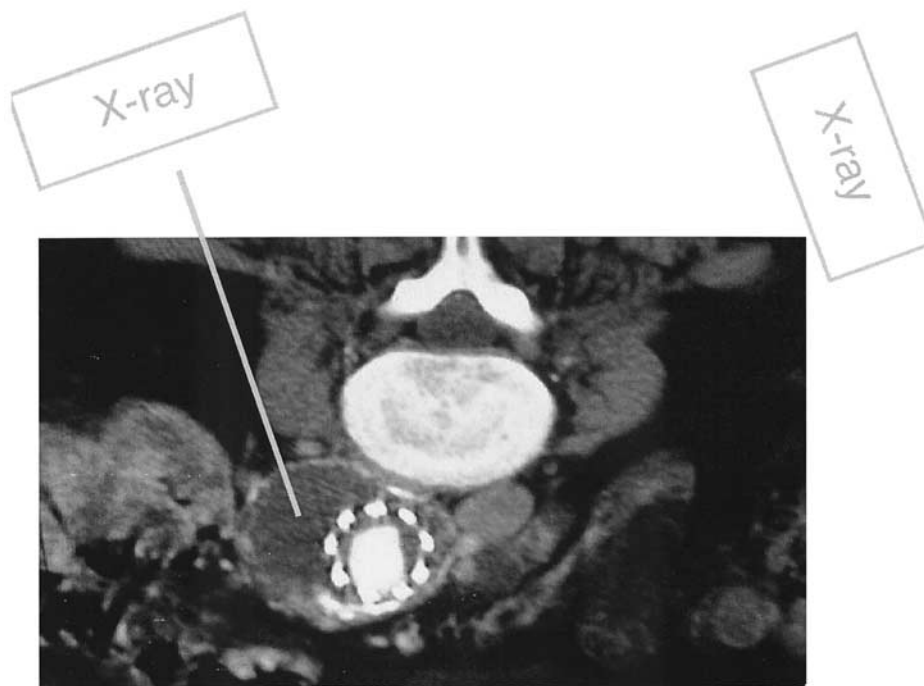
Axial CT scan shows intended line of puncture. *Left*, “Down-the-barrel” position of x-ray tube; *right*, perpendicular position of tube for depth evaluation.
